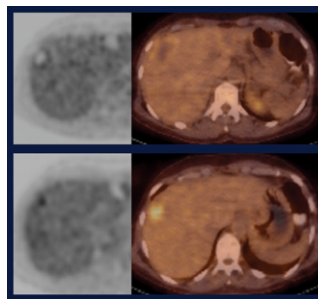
PET/CT after radiofrequency ablation of colorectal liver metastases. Top images show rim-shaped uptake adjacent to photopenic radiofrequency ablation zone at 3 months. Bottom images show focal uptake at 6 months, which is highly suggestive of local-site recurrence.
